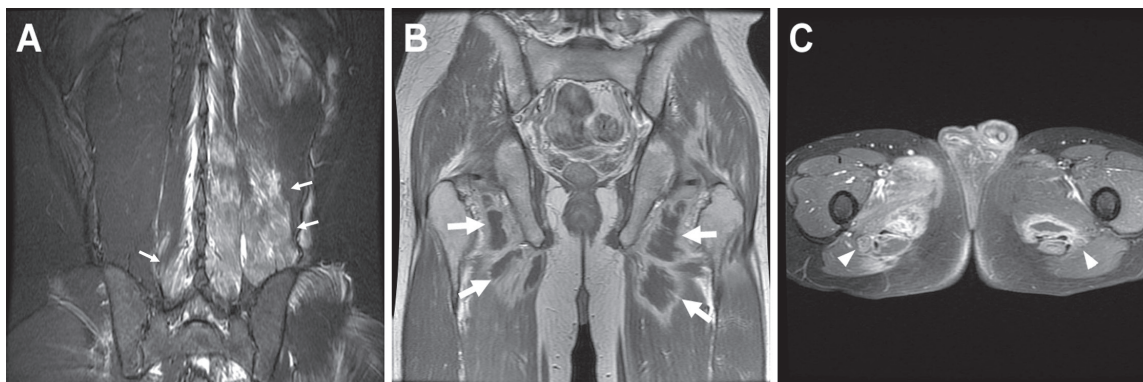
(A) Coronal STIR MR image of lumbar spine shows diffuse high signal intensity of paraspinal and gluteal muscles, predominately on the left side (small arrows). (B) Coronal T1-weighted MR image after intravenous gadolinium administration shows myonecrosis of bilateral adductor muscles (arrows). (C) Transaxial fat-suppressed T1-weighted MR image after intravenous gadolinium administration shows myonecrosis of bilateral adductor and hamstring muscles. Enhancement of bilateral enlarged sciatic nerves is also seen (arrowheads).
